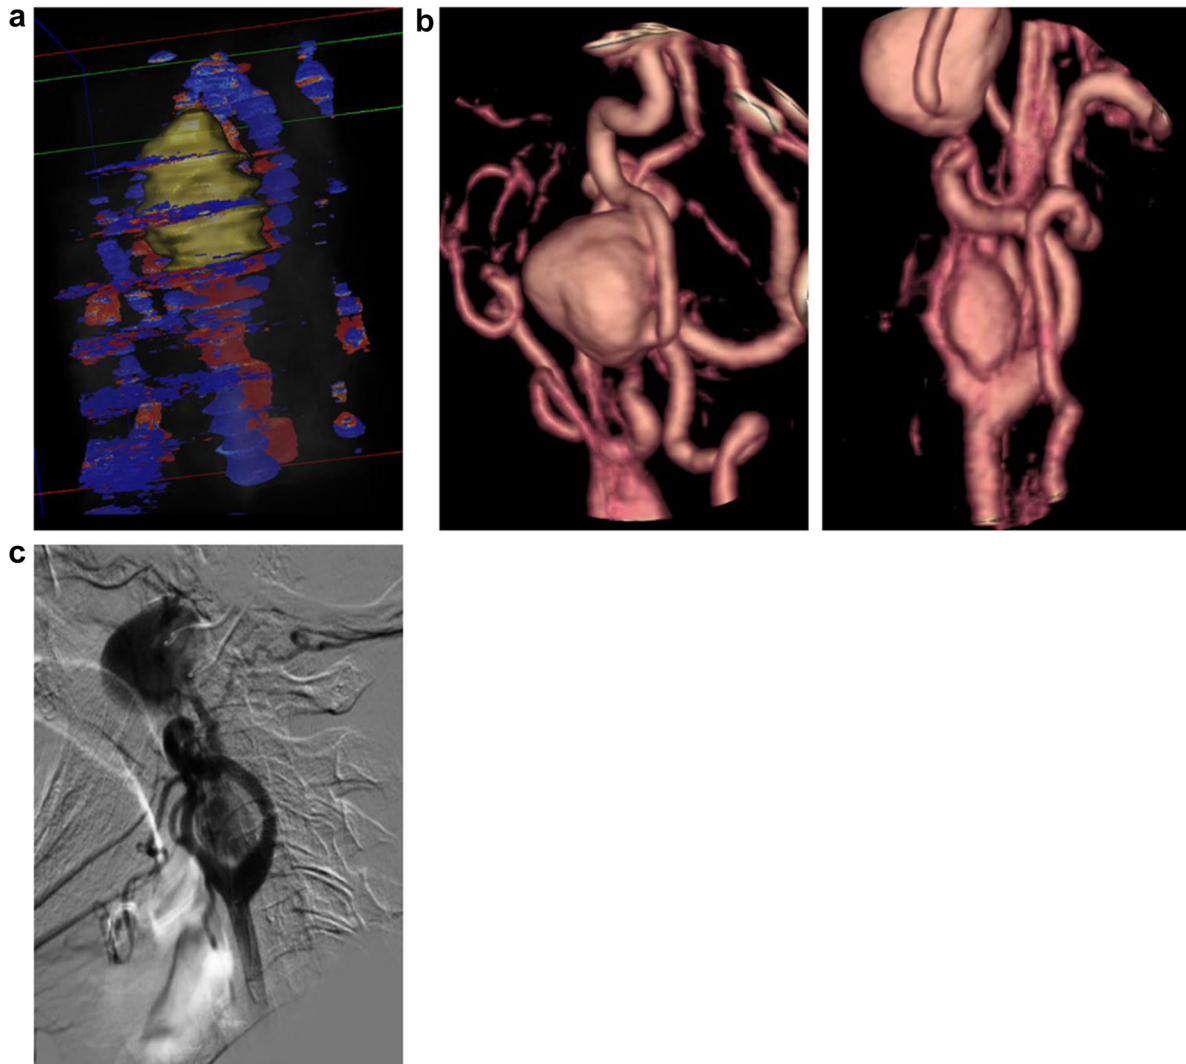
a, A three-dimensional (3D) carotid duplex shows a 1.68-cm \times 1.3-cm well-vascularized echogenic mass splaying the carotid bifurcation. b, A 3D reconstruction of a magnetic resonance image shows a distal cervical segment internal carotid artery (ICA) aneurysm and carotid body tumor (CBT). c, A catheter angiogram shows the tortuosity of the ICA.
